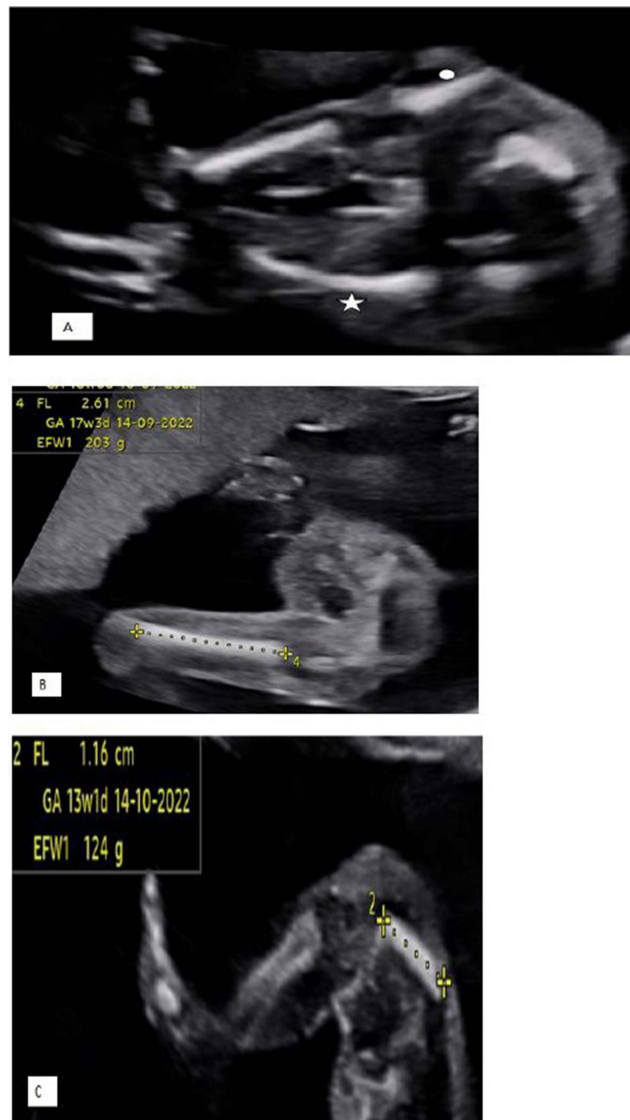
Ultrasound image (A) -shows both the normal femur (marked with a star) and the affected femur (marked with a circle) in the extended lower extremities. Image (B) -focuses on the normal femur, while image (C) -highlights the affected femur of the same fetus with PFFD.
